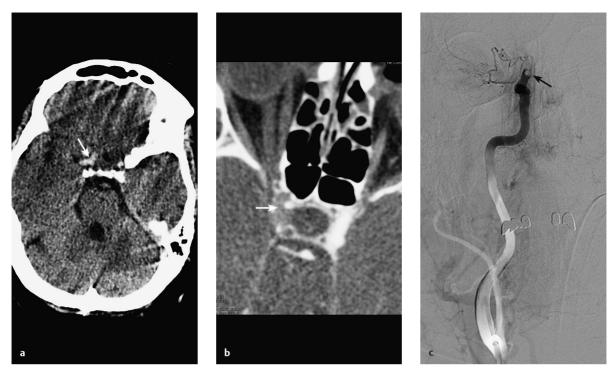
Acute embolic occlusion of the carotid T. a The hyperdense embolus is clearly visualized on cranial CT (*arrow*).
